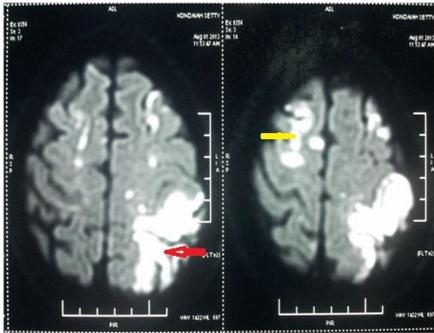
MRI brain showing hyper intense signals in ACA territory both sides.
